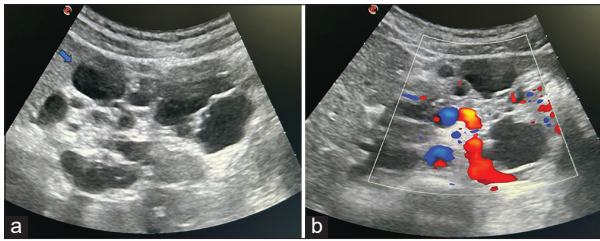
(a) Ultrasonography W/A showing multiple hypoechoic cysts in the pancreas (arrow), (b) Doppler ultrasound revealed multiple well-defined lesions with no color flow or vascularity
